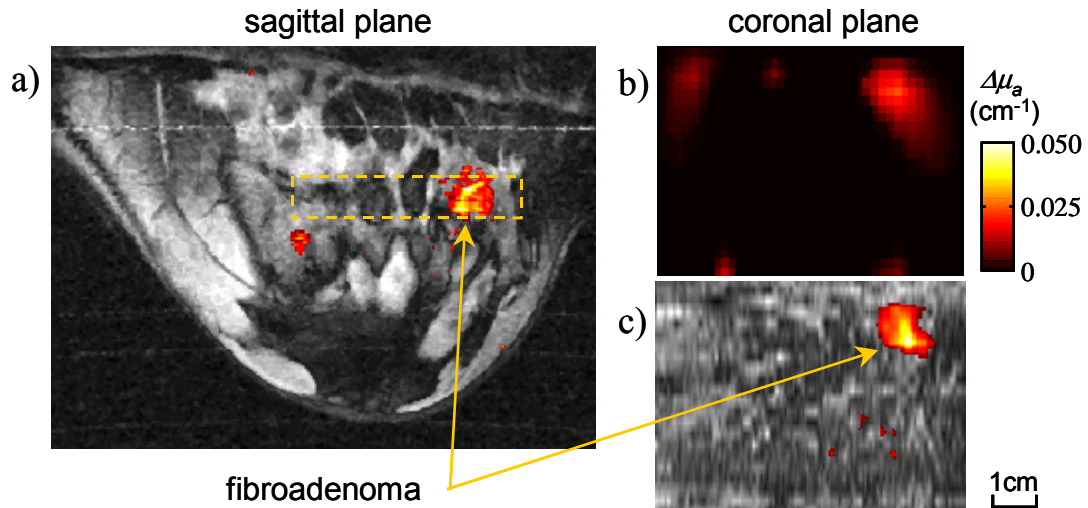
Fibroadenoma. (case II) *a)* Functional sagittal MR image after Gd contrast enhancement passing through the fibroadenoma. *b)* Coronal DOT image, perpendicular to the plane of the MRI image in (a), for the *volume of interest* (VOI) indicated on (a) with the interrupted line box. *c)* Functional MR coronal re-slicing of the VOI with the same dimensions as (b).
